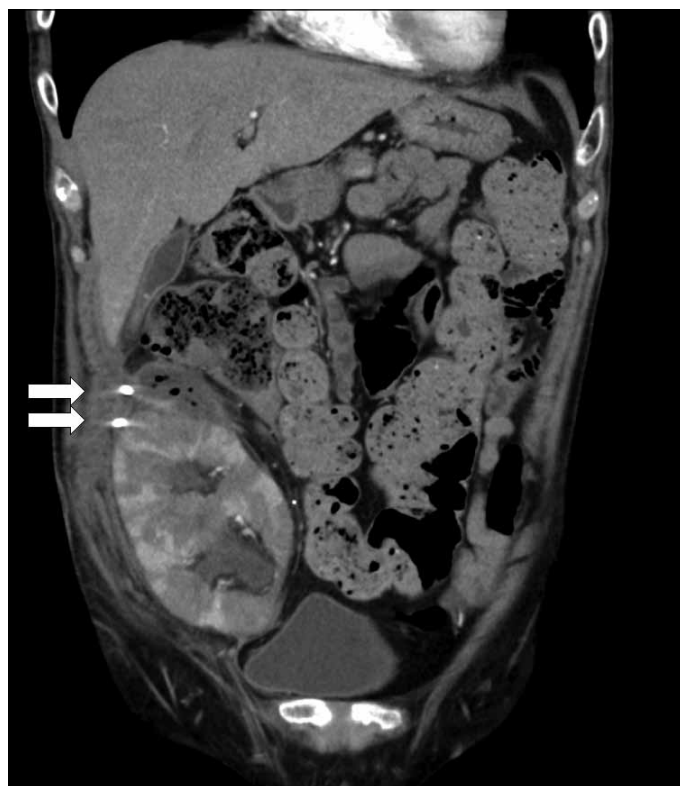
An early follow-up computed tomography scan shows a decrease of abscesses and two drainage tubes.
